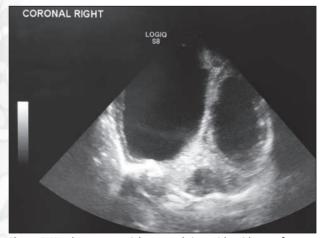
Head sonogram: right coronal view with evidence of severe dilatation of the lateral ventricles, more pronounced on the right.
